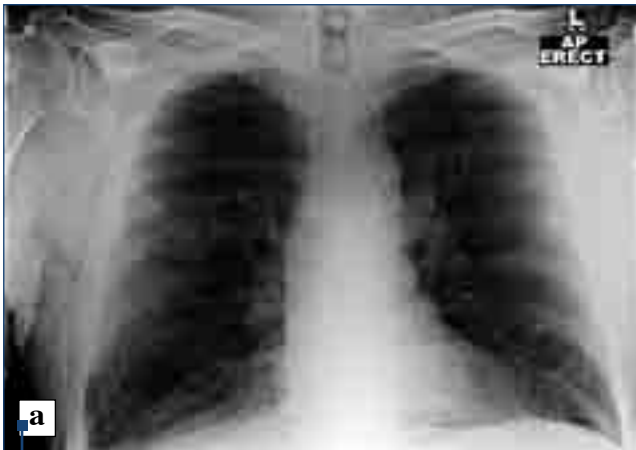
Pleural effusion. Chest radiograph (a) and pleural ultrasound (b)
